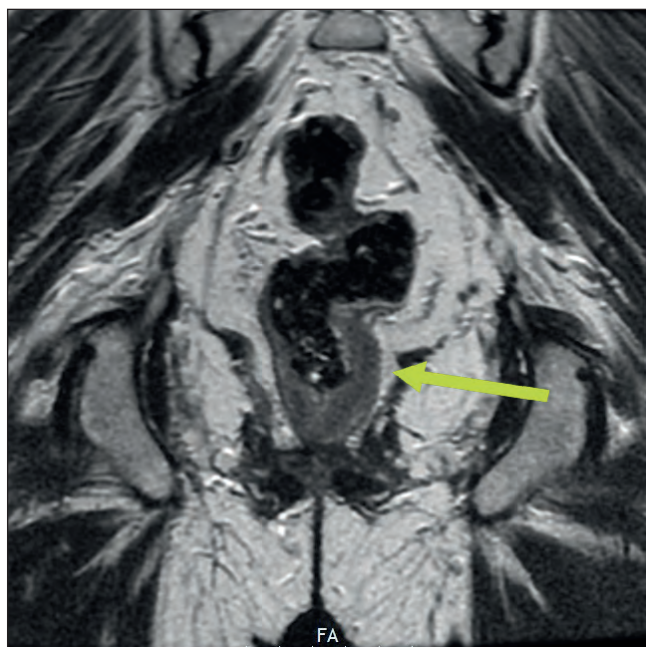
MRI view (coronal) demonstrating the low rectal lesion
